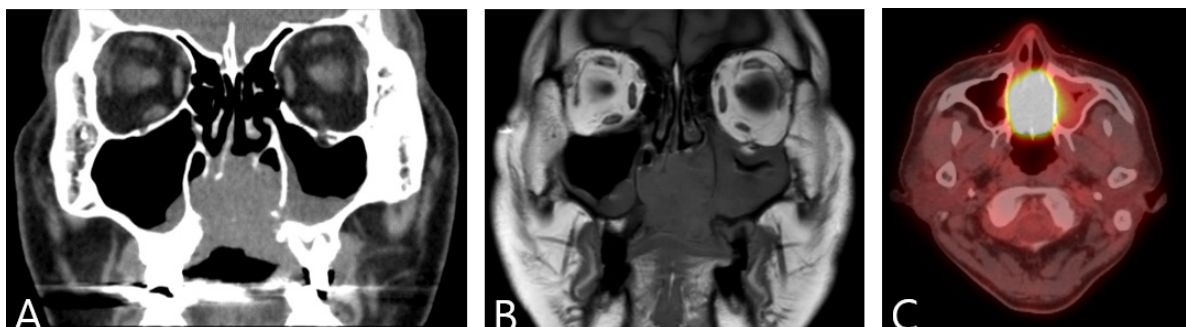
(A) Computed tomography(CT) in coronal view
